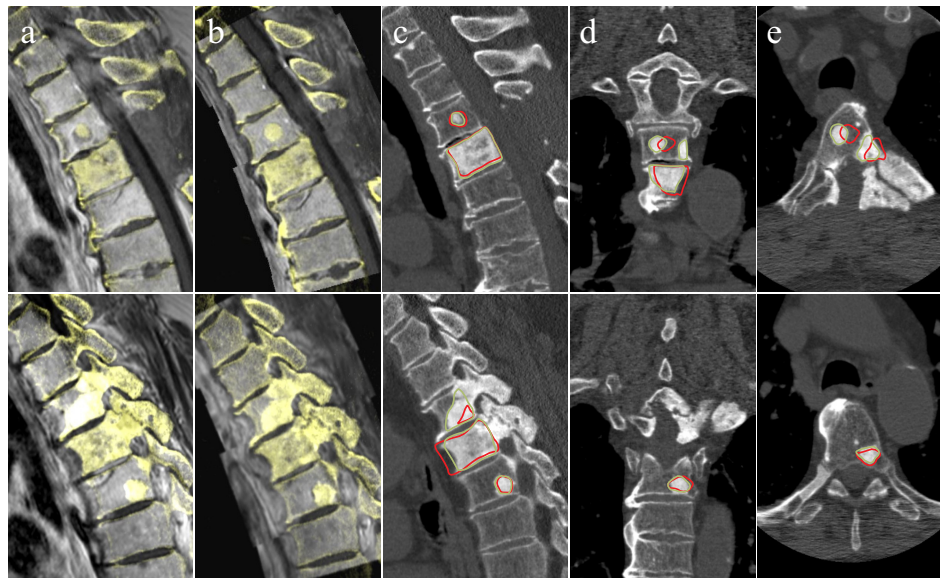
Comparison of fused images using a globally rigid (a) and a multisegmental (b) registration approach. Shown are a mid-sagittal (top row) and lateral (bottom row) cross-section of an exemplary patient case. Additionally, the masks of previously segmented metastases were transformed according to the resulting transformation matrices of the globally rigid (red contours) and the proposed multirigid approach (green contours). Sagittal (c), coronal (d) and axial (e) cross-sections of the FP-CT scan are shown with overlaid metastasis contours. The FRE_{GR} of this patient case was 4.58 mm and the FRE_{MS} was 1.84 mm.
